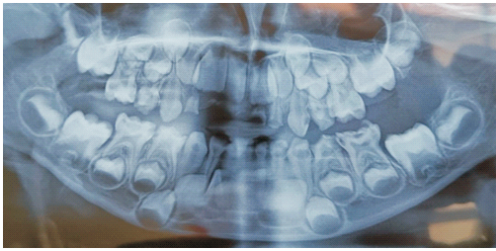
Case 1- Radiographic investigation (Orthopantomogram)
